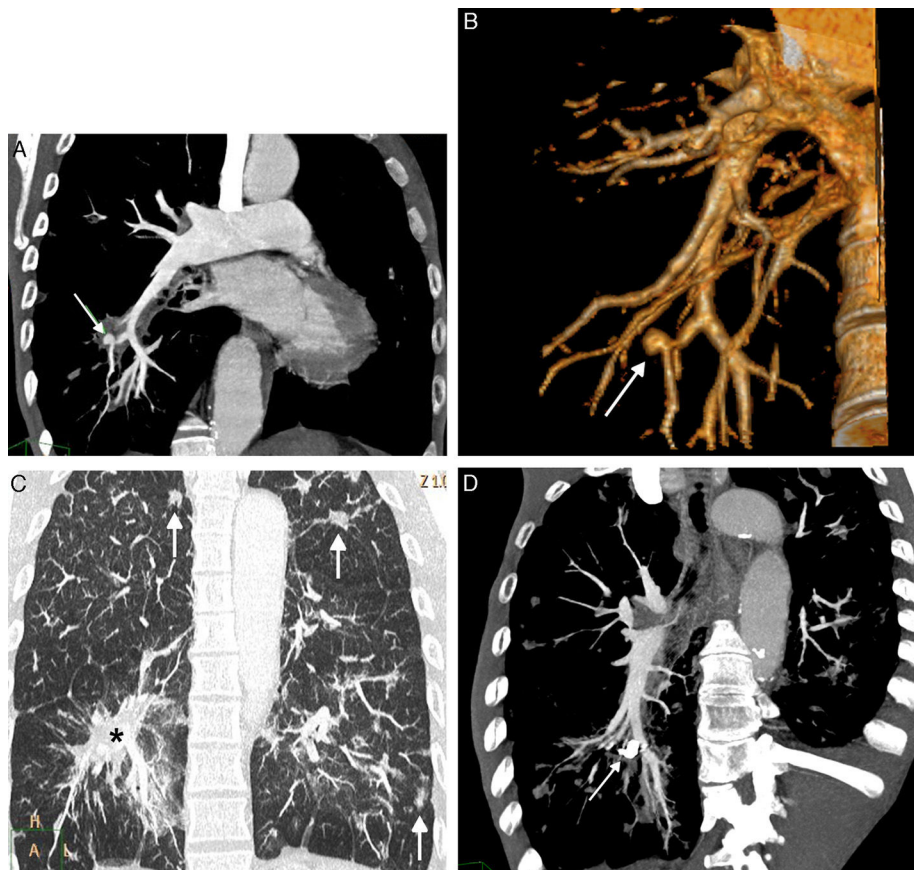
(A) Coronal maximum intensity projection (MIP) CT reconstruction, showing a Rasmussen's aneurysm (arrow) on a subsegmentary branch of the right lower lobe artery. (B) CT volumetric reconstruction (3D or volume rendering) confirming Rasmussen's aneurysm (arrow). (C) Coronal MIP CT reconstruction (pulmonary parenchyma window) showing signs of lung hemorrhage (asterisk) and bilateral residual infectious parenchymal opacities (arrows). (D) Coronal oblique MIP CT reconstruction after embolization showing embolization material (coil) occluding the Rasmussen's aneurysm (arrow).
